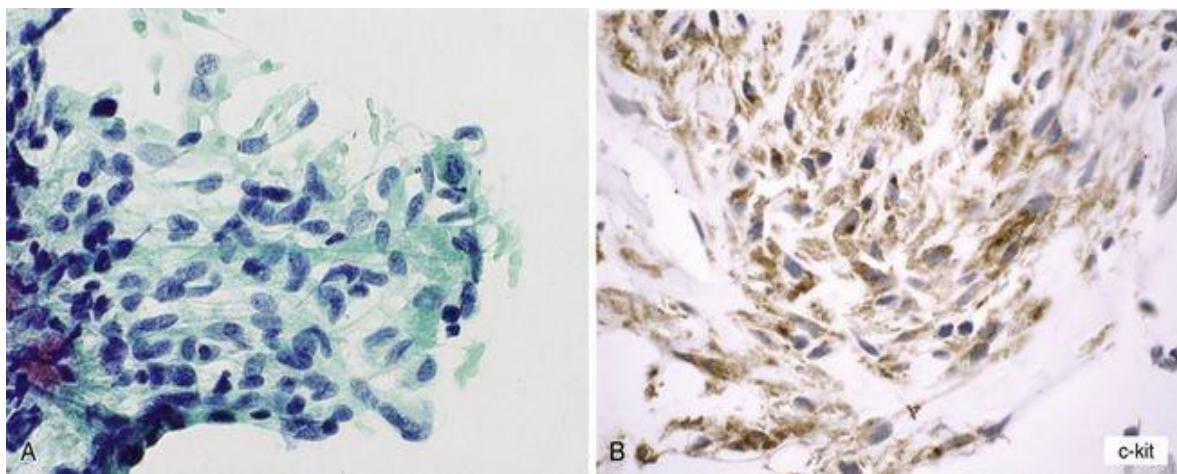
Gastrointestinal stromal tumor (GIST) (ultrasound-guided endoscopic fine-needle aspirate [FNA] of a gastric mass).
